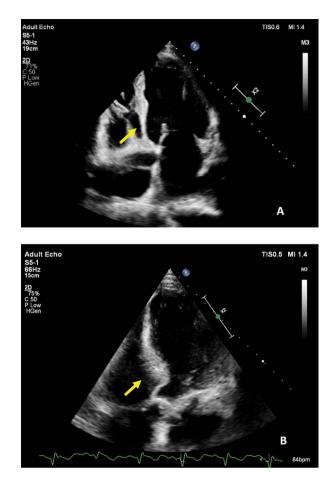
Rupture and dissection of the inferior septum (indicated by the arrows) before (A) and post-surgical repair (B) of ventricular septal defect with a Dacron patch (apical 4-chamber view)
